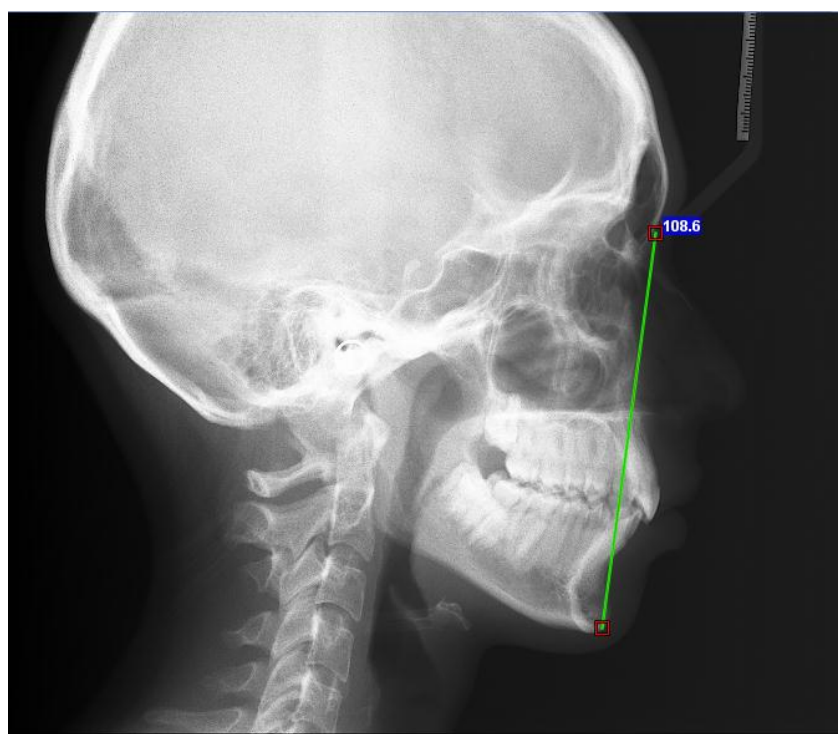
Lateral cephalometric radiograph showing the measurement between N to Gn
